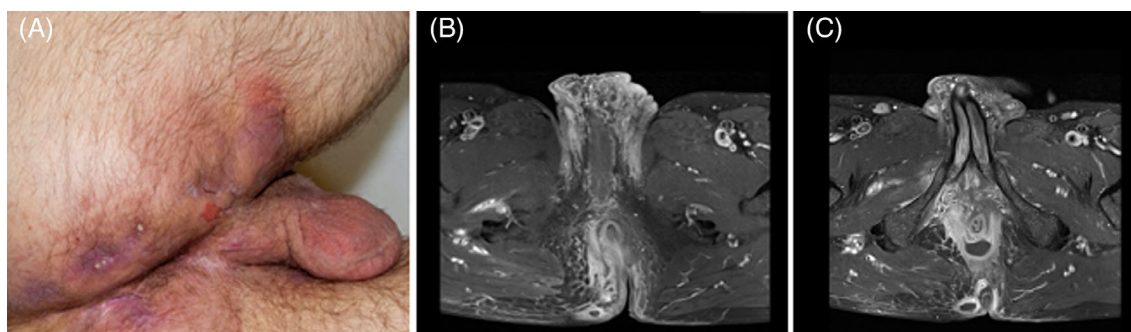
Case 1 showing advanced stage hidradenitis suppurativa with vast absceding inflammation. (A) preoperative clinical condition, (B) preoperative MRI with sphincter involvement, and (C) extensive abscess formation
